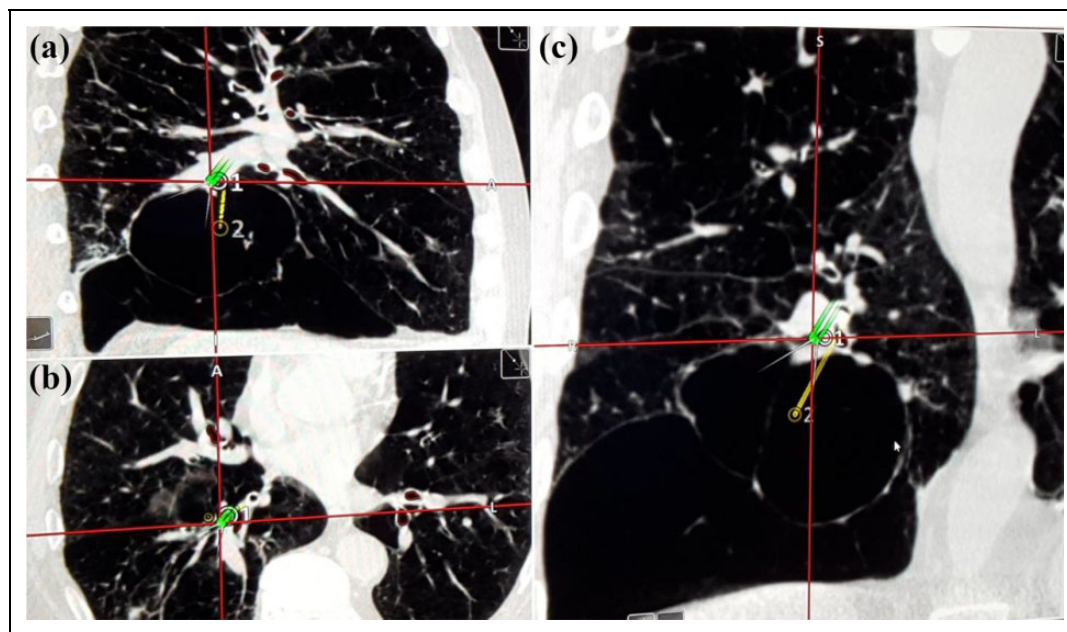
HRCT-based 3-D navigation for bulla puncture. Based on a previous HRCT, target areas for the bulla puncture (marked as 1) and the center of the largest bulla (marked as 2) were predefined. The light green double line presents tip of the navigation probe in its actual position in the coronal (a), transverse (b), and sagittal (c) plane reaching the predefined puncture point of the bronchus (1). The yellow line marks the shortest track to the target area (2)—the center of the bulla. HRCT: high-resolution computed tomography.
